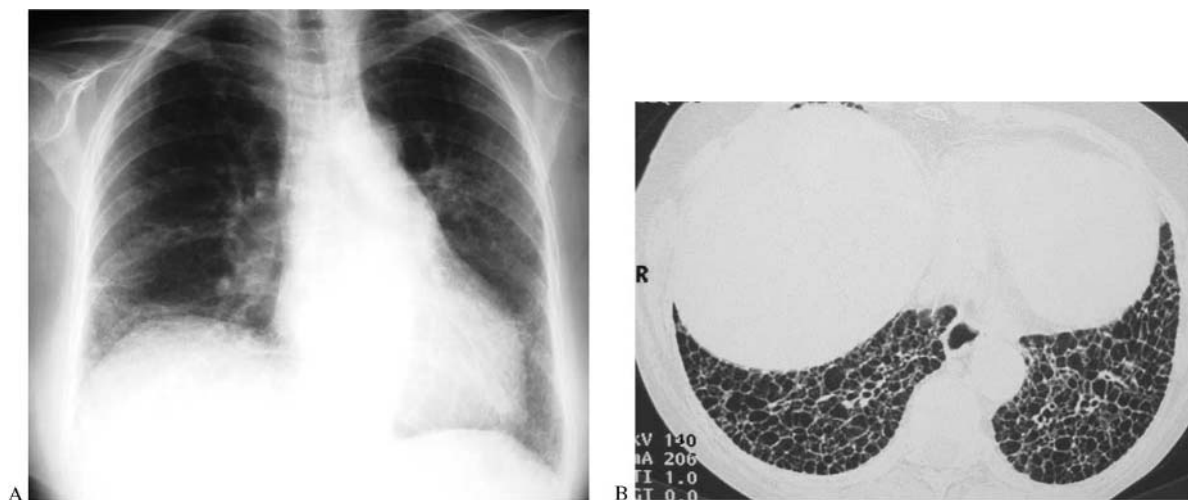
Chest radiograph in a patient who has progressive systemic sclerosis. (A) Bilateral ill-defined opacities are present in both lung bases. (B) Corresponding CT scan shows typical features of interstitial lung fibrosis (honeycombing). Dilatation of the esophagus is also noted.
